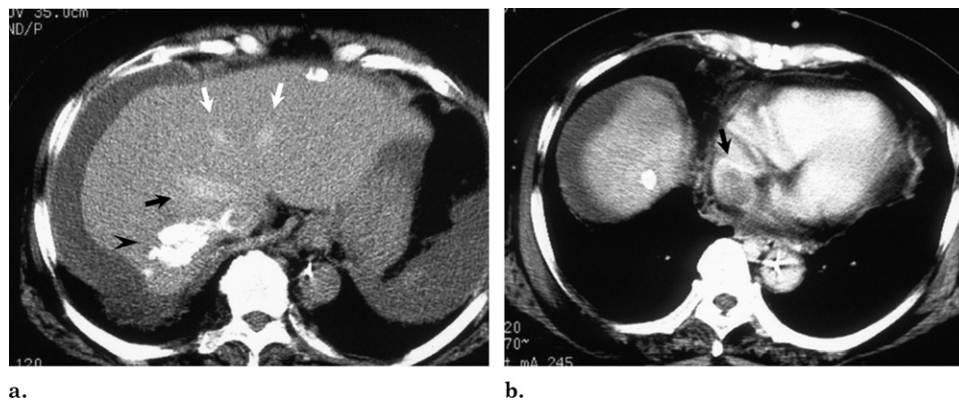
(a) Unenhanced CT image reveals high density because of acute thrombus formation in LHV (white arrows) and middle HV (black arrow). Calcification of liver metastases in the RHV are indicated by the arrowhead. (b) Enhanced CT image shows tumor thrombus extending from the RHV to the RA (arrow).
